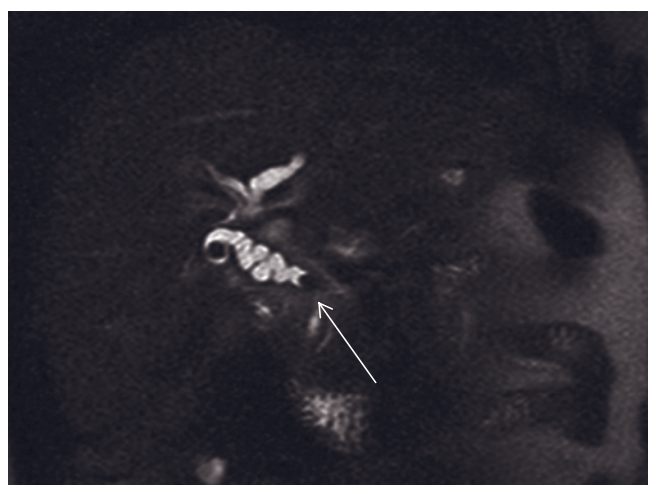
Ampullary choledocholithiasis. Coronal (a) and transverse (b) T2-weighted single-shot echo-train spin-echo images and coronal thin-section MRCP single-shot echo-train spin-echo image with fat suppression (c). Multiple small low-signal calculi are demonstrated in the gallbladder (a, b). The CHD and CBD (arrows, a, b) are dilated but no intraductal stone is visualized on the 8-mm coronal and transverse images (a, b). The thin-section MRCP image (c) reveals a small choledocholith (arrow, c) that is lodged in the ampulla and obstructs the CBD. The duodenum is filled with fluid outlining its folds (a, c). High-signal cysts are incidentally revealed in the dome of the liver (a) and the left kidney (a, b). Paracoronar thick-section MRCP (d), thin-section MRCP (e), and axial T2-weighted single-shot echo-train spin-echo
